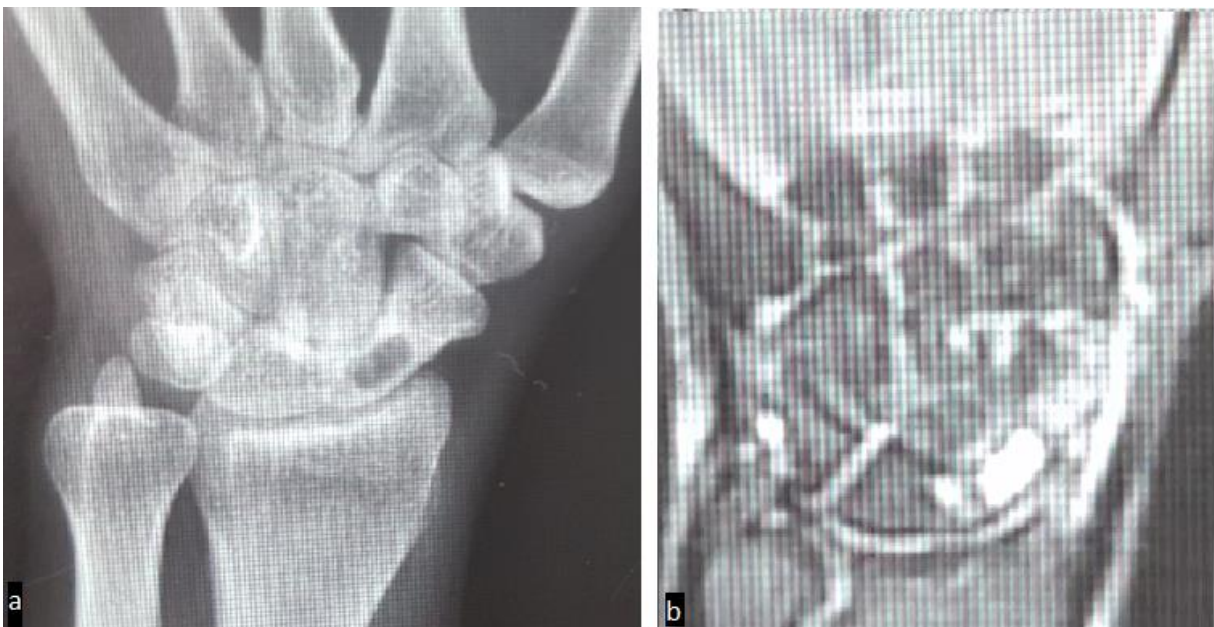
Photoroentgenogram of the left hand ( a ) and MRI scan ( b ) of patient R., born in 1990. No. 722/2729 ( description in the text)
